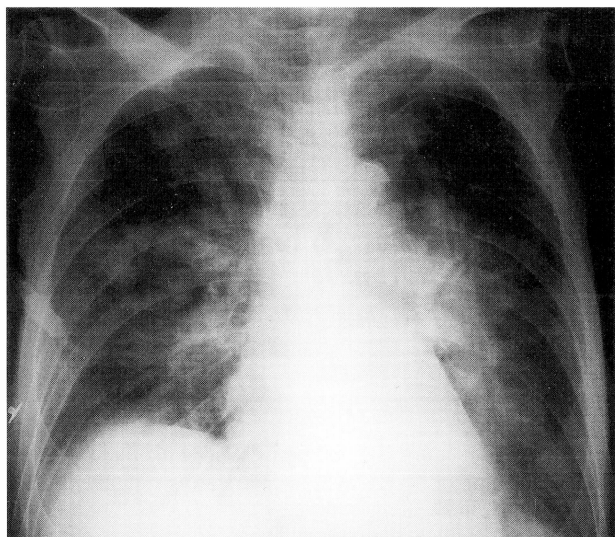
Chest X-ray film shows diffuse abnormal shadows in bilateral lung fields.
